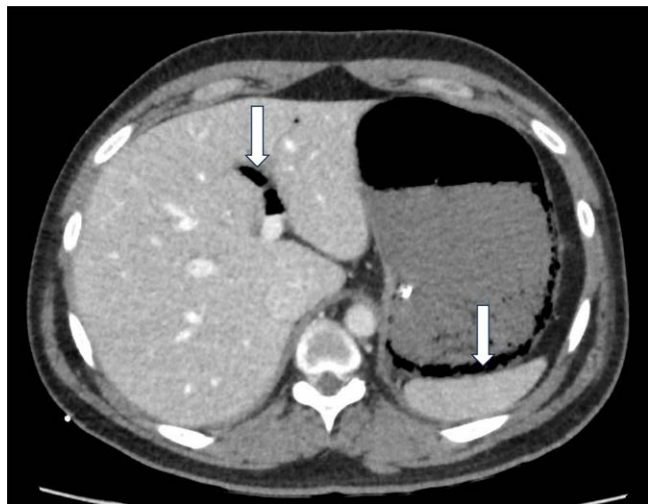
Portal venous phase of the CT scan performed 1 d before procurement in donor 2 showing intramural gas in the stomach and gas within the left portal vein (both marked with arrows). Other slices showed peripheral distribution of portal venous gas. CT, computed tomography.
